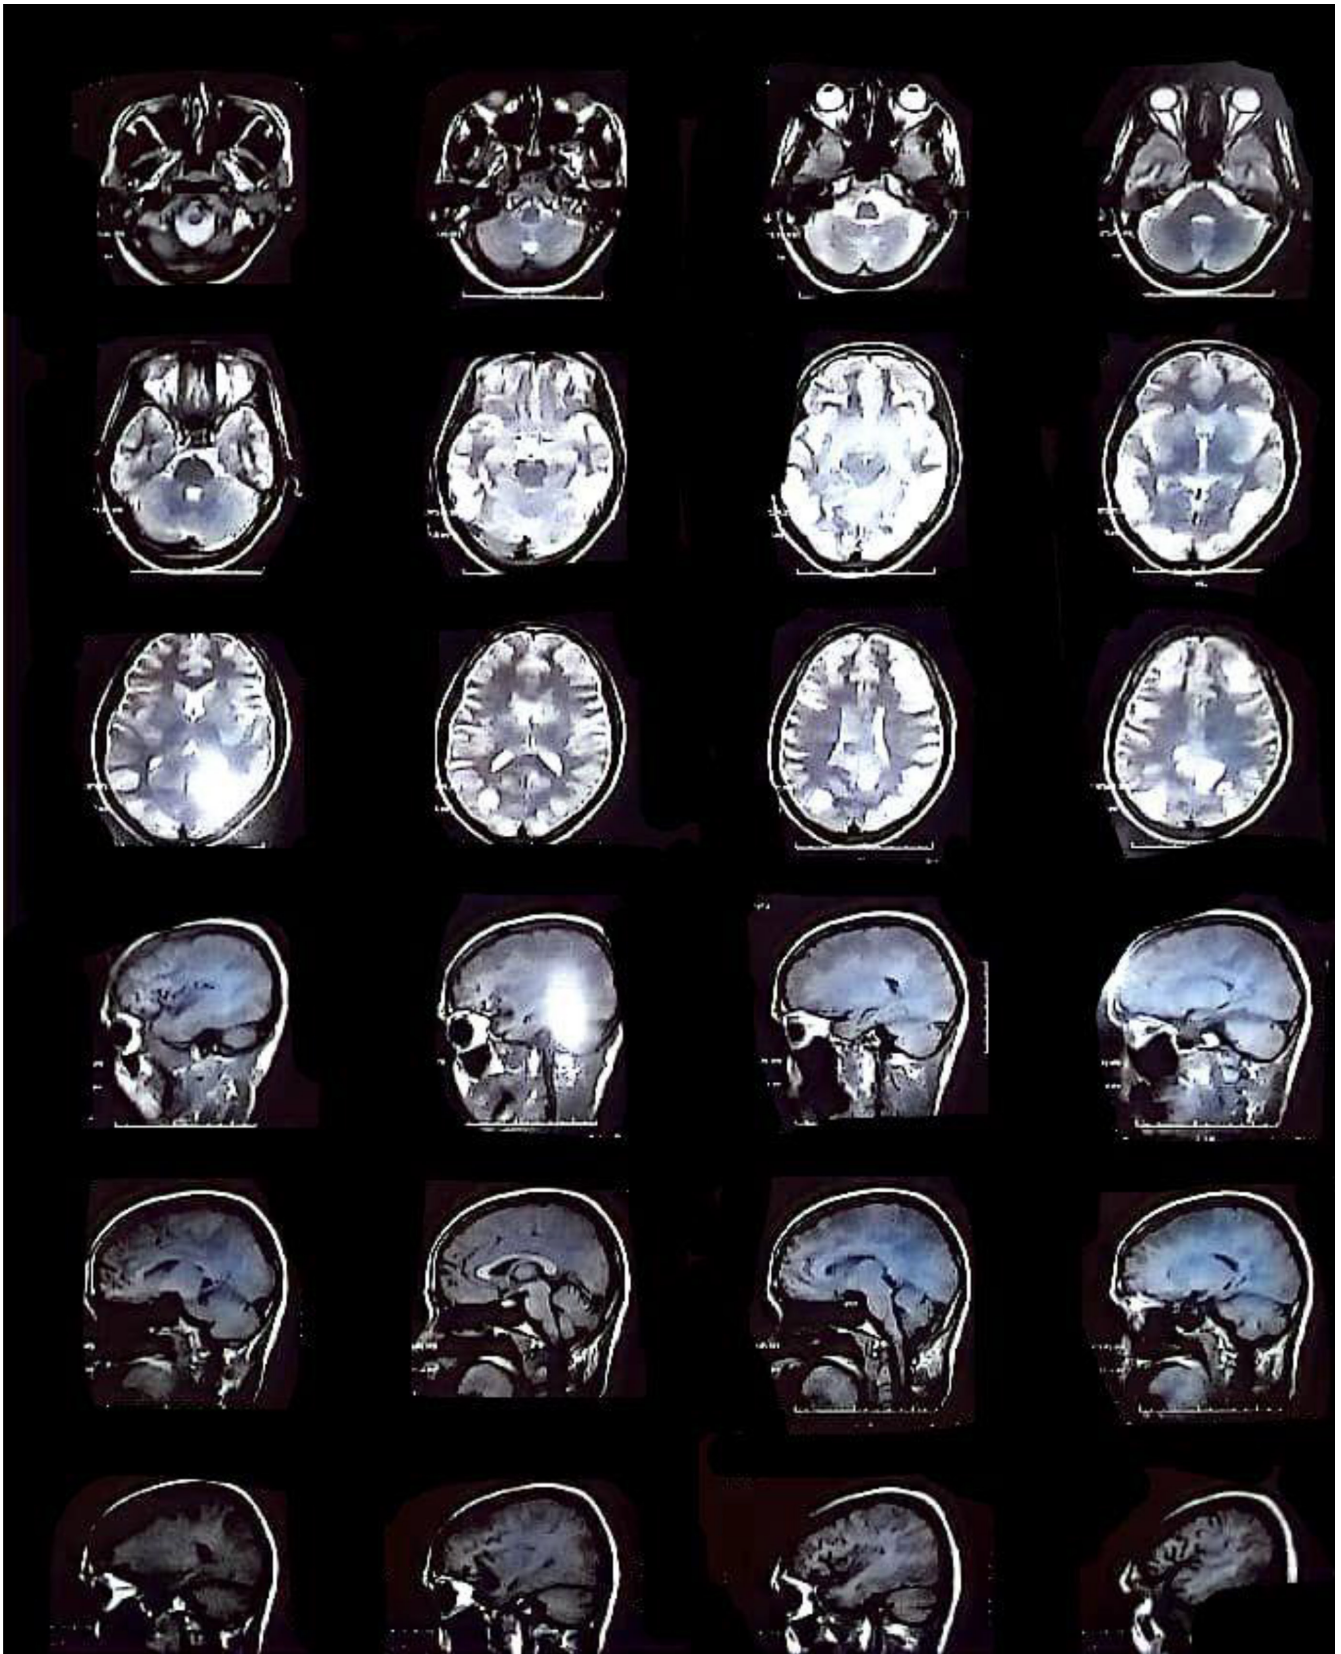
MRI with T2 signals. There are multiple bilateral and nearly symmetrical areas of T2 shown in MRI. Indeed it is playing a pivotal role in making the diagnosis of PRES.
